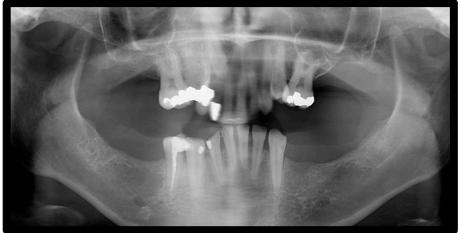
An earlier panoramic radiograph 01.12.2008
